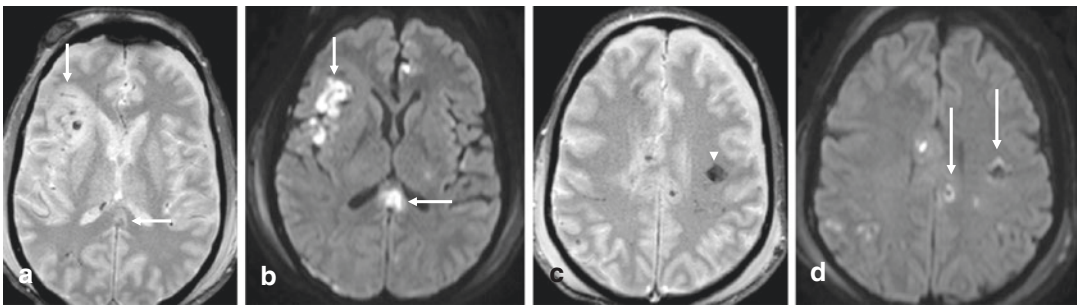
(a–d) DAI grade 2. 25-year-old female after high-speed MVA. Multiple nonhemorrhagic and hemorrhagic (arrowhead in c) lesions seen on DWI (b, d) and GRE (a, c) sequences. The nonhemorrhagic DAI lesions in the splenium of the corpus callosum (b) and near the right sylvian fissure (b) are better seen on DWI. DWI is
